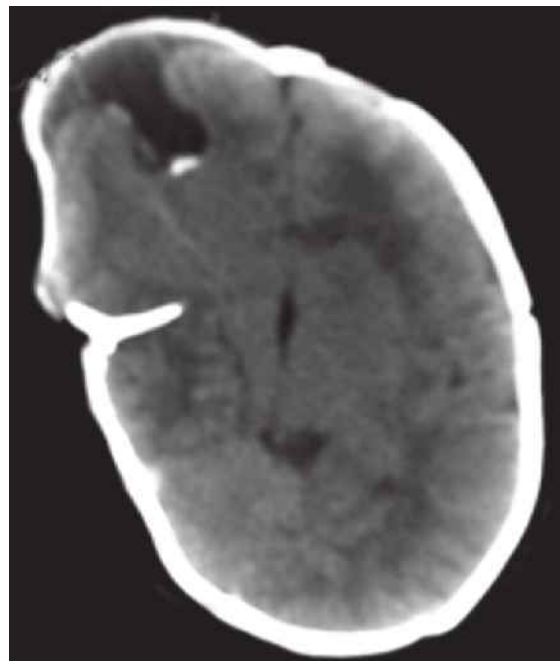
Axial CT image shows right frontal encephalocele with cyst in the right frontal lobe, marked pachygyria. There was no hydrocephalus.
